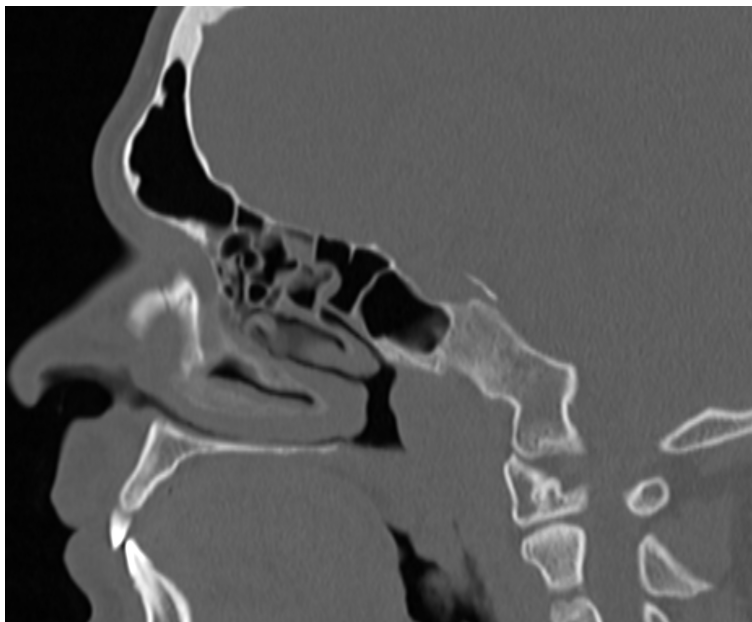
Computed Tomography Scan of a Human Head
